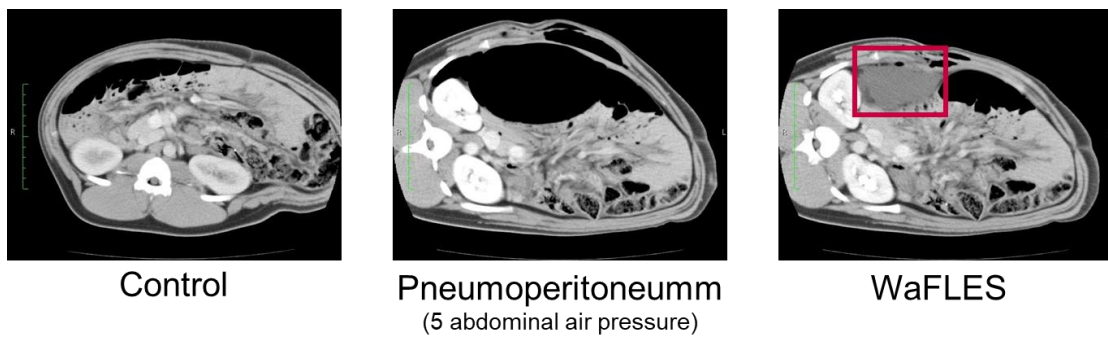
The comparison using the CT images when securing the surgical field (The red frame in the WaFLES's CT image is the operative field space in the liquid by the WaFLES technique)
